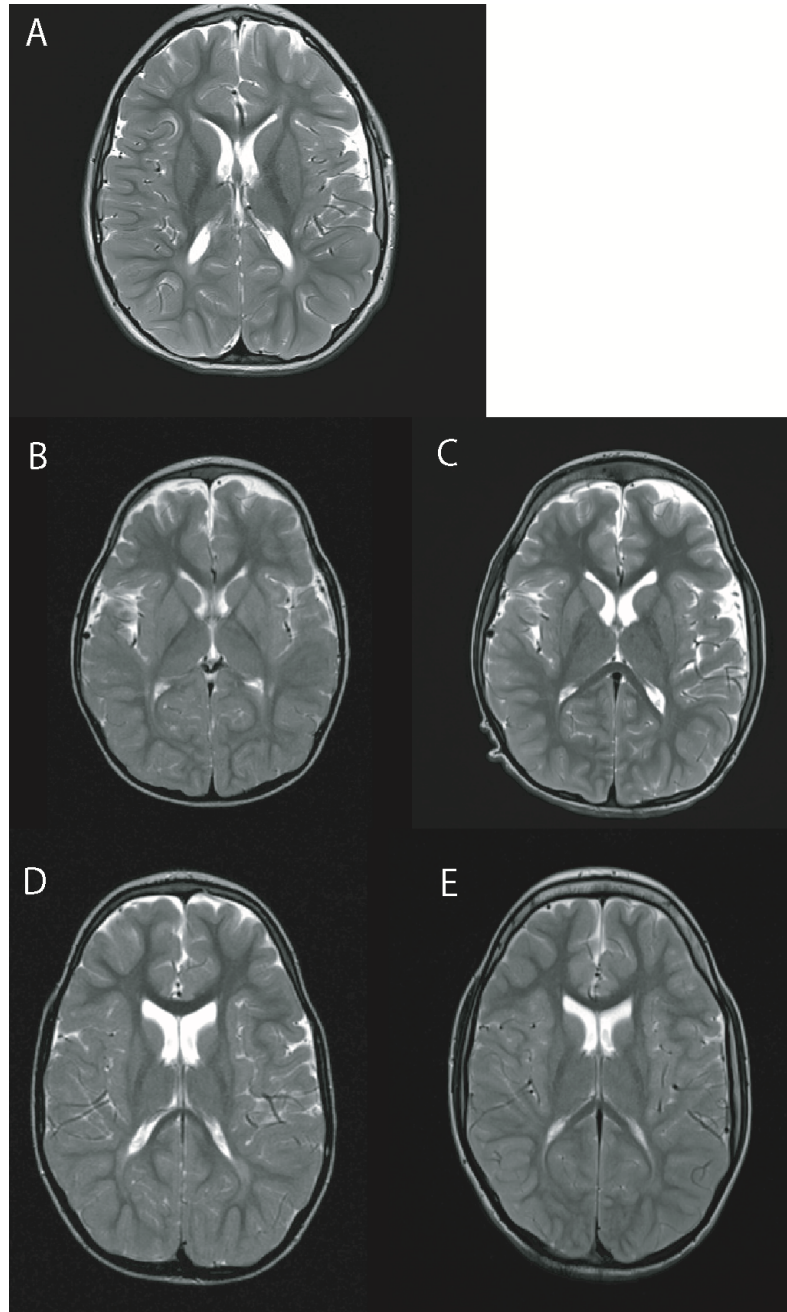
Brain MRI findings in patients with bi-allelic *PNPT1* variants. T2-weighted axial view showing (A) generalized neuroparenchymal volume loss with a posterior predilection in patient 2 at 5 years, (B) mild white matter atrophy in patient 5 at age 3 years and (C) at 11 years, (D) decrease in white matter plus non-specific white matter changes in the periventricular and parieto-occipital regions in patient 6 at 5 years and (E) at 13 years.
